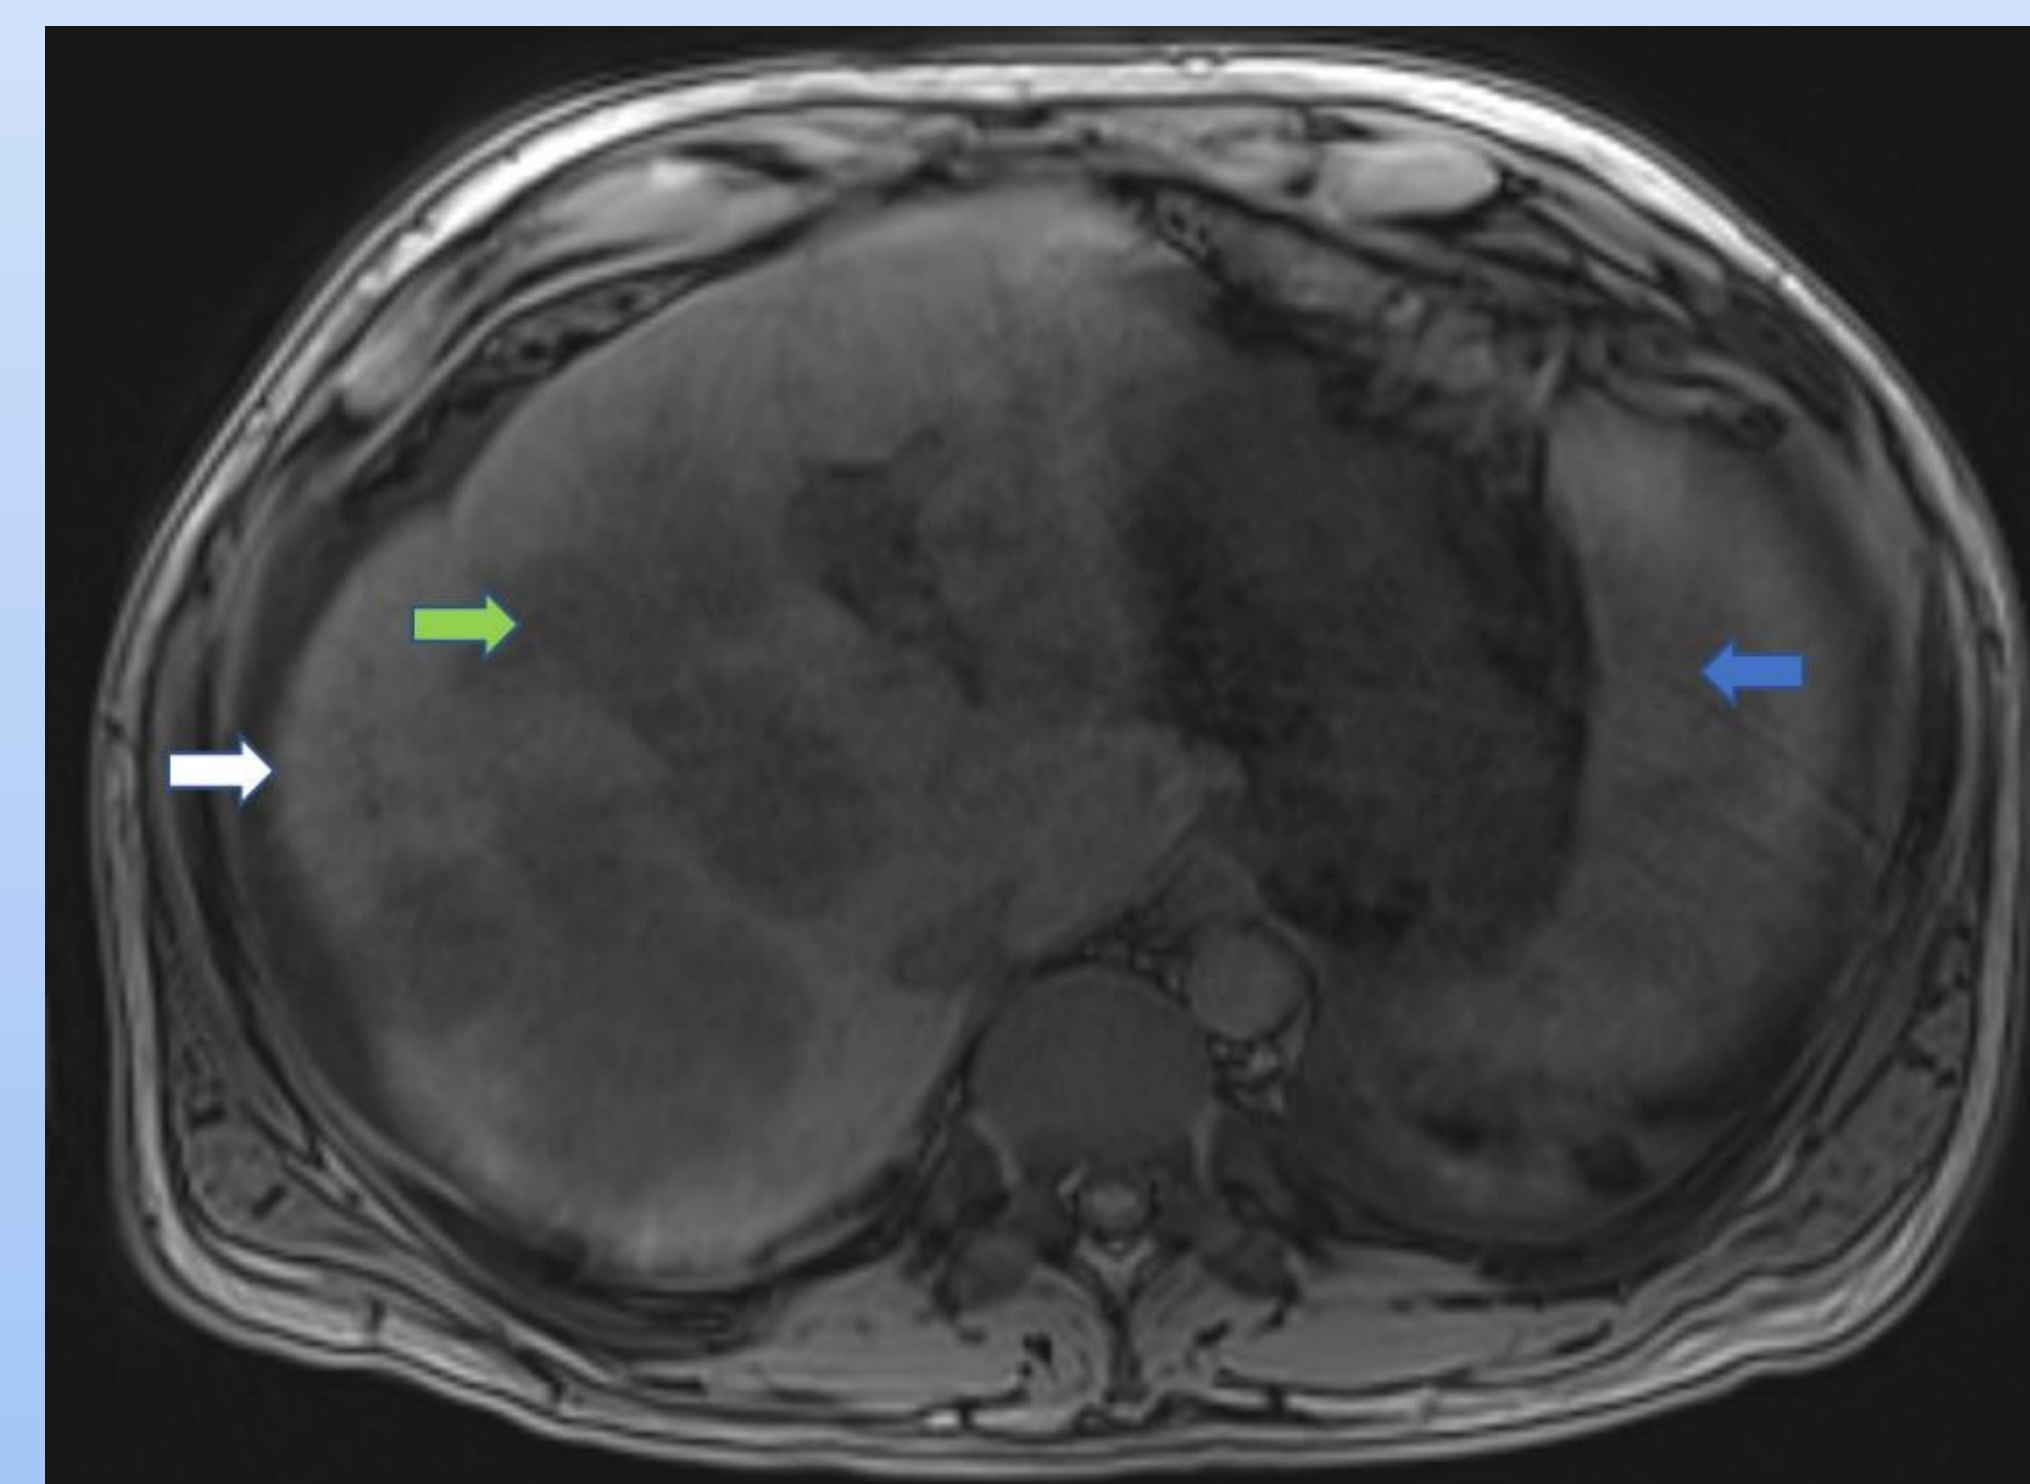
MRI abdomen showing nodular liver contour (white arrow), metastatic disease (green arrow), and splenomegaly (blue arrow)
